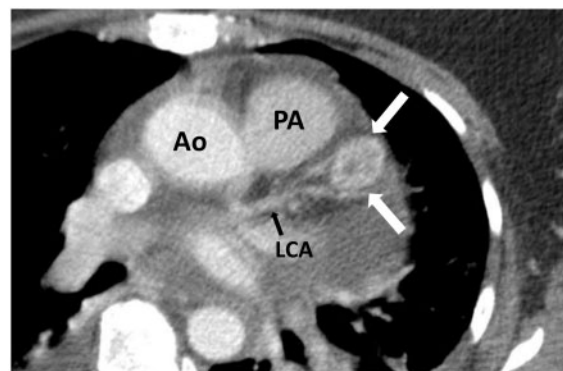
Computed tomography showing circumscribed mass (arrows) measuring $20 \times 22 \times 8$ mm attached to the anterior wall of the left ventricle in proximity to the left anterior descending artery. Ao, ascending aorta; LCA, left coronary artery; PA, pulmonary artery.
